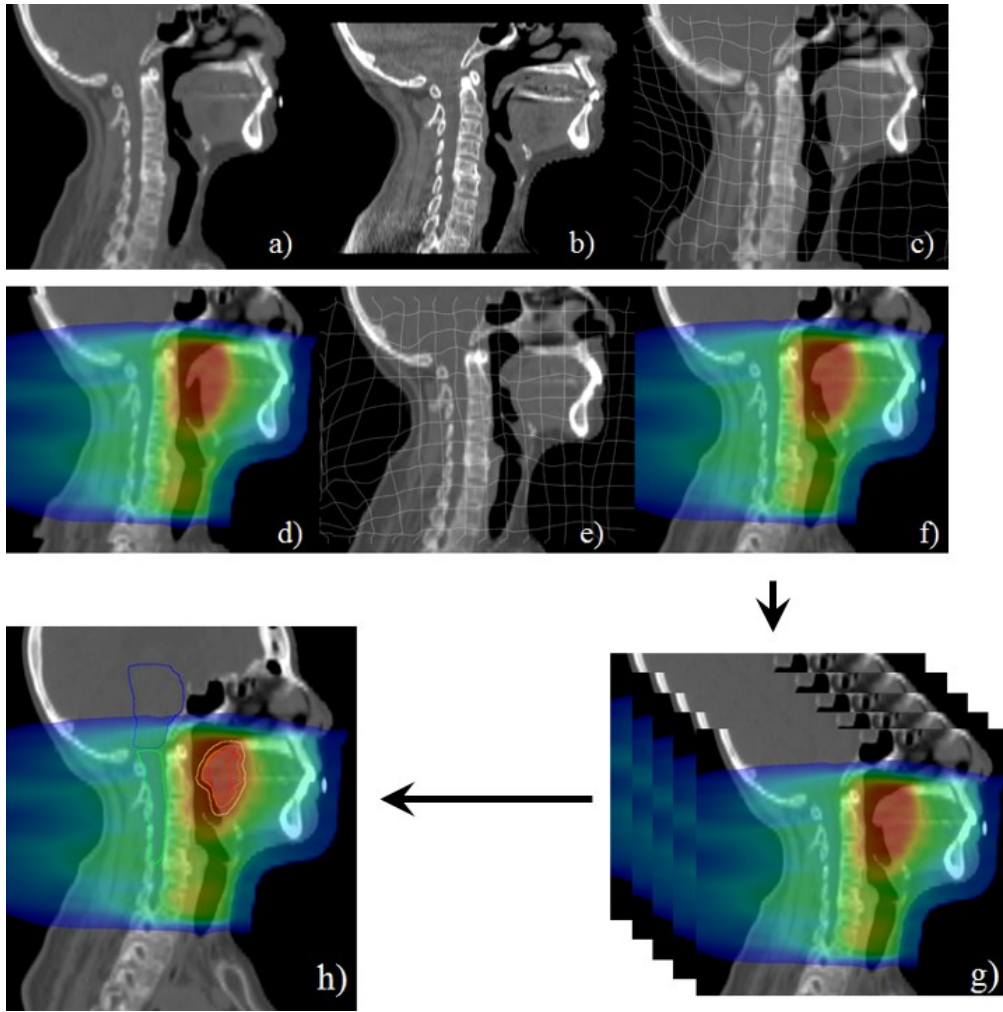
The all-to-one dose accumulation procedure. A planning computed tomography (pCT) scan (a) is matched to a cone beam CT (CBCT) scan (b) to generate a deformation vector field (DVF) and a deformed pCT (dCT) (c). The plan (beam arrangement, monitor units, fluence maps) is then recalculated (d) on the dCT. The inverse DVF (e) is applied to the recalculated dose and the resultant dose distribution is reconstructed in the pCT space (f). Reconstructed doses of successive fractions can be accumulated (g) in the pCT space (h).
